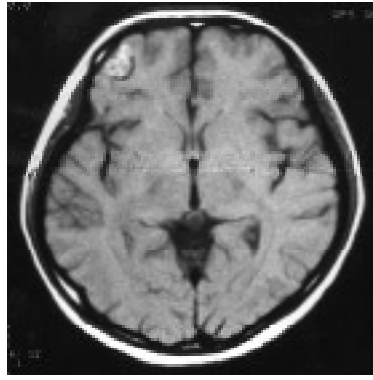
Previous axial T1-weighted MR image of same patient as Figs. 1-2 shows a subtle right frontal lobe heterogeneous signal intensity focus with surrounding low signal rim.
